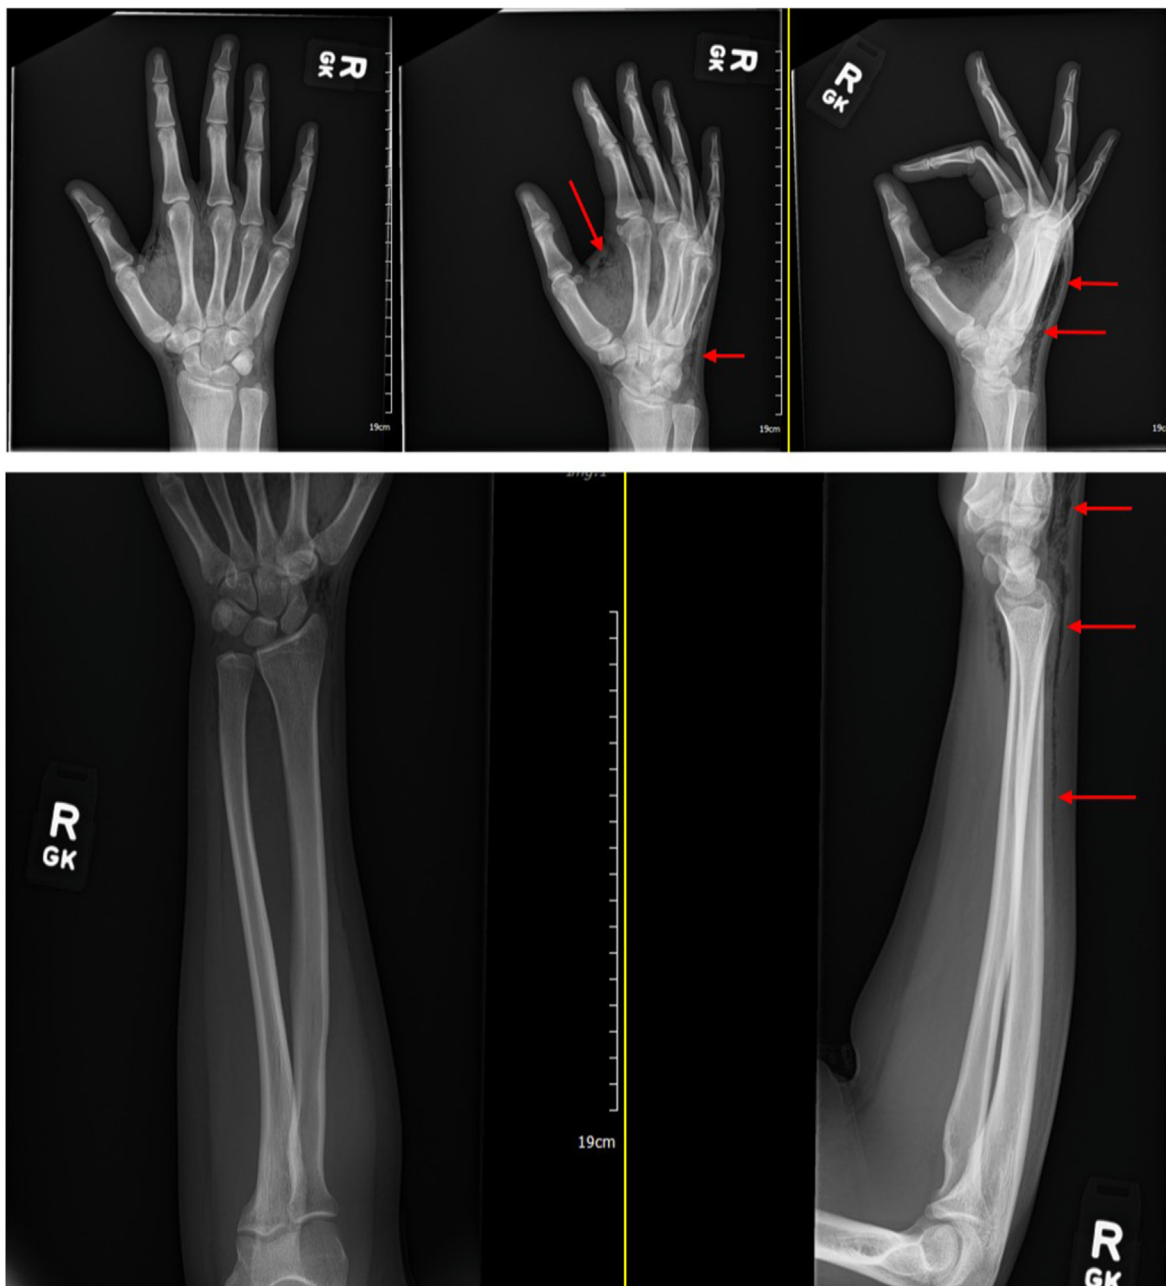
Plain radiographs of the right hand and forearm demonstrating air confined to the subcutaneous tissue layer that does not appear to divide the muscular tissue or have heterogeneous invasion through various tissue planes.
